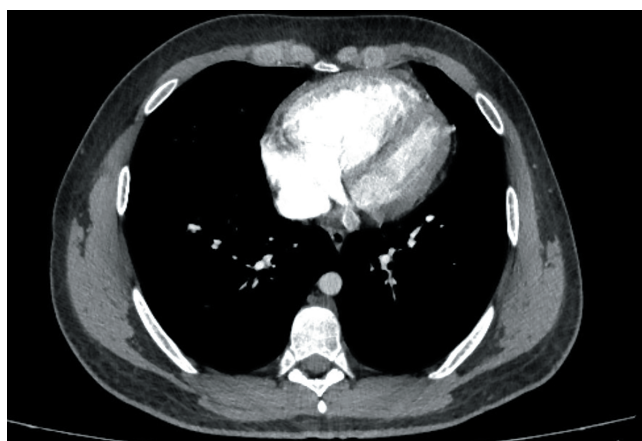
Contrast-enhanced chest CT scan transversal sections showing evidence of dilated right heart.
